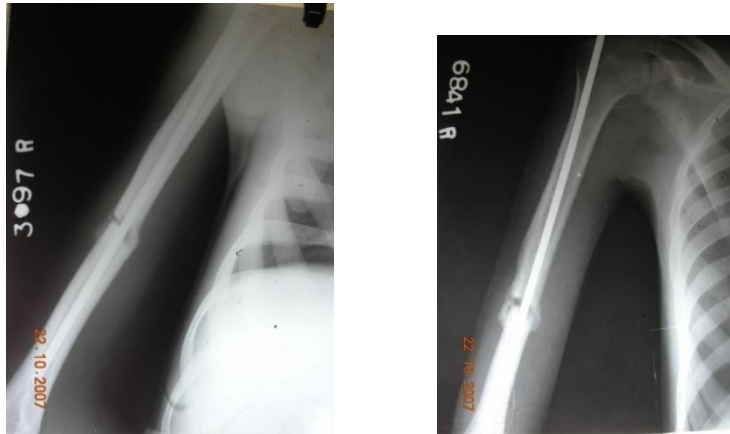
Radiographs at 2 months showing bridging callus on either side of the fracture both anteriorly and posteriorly
